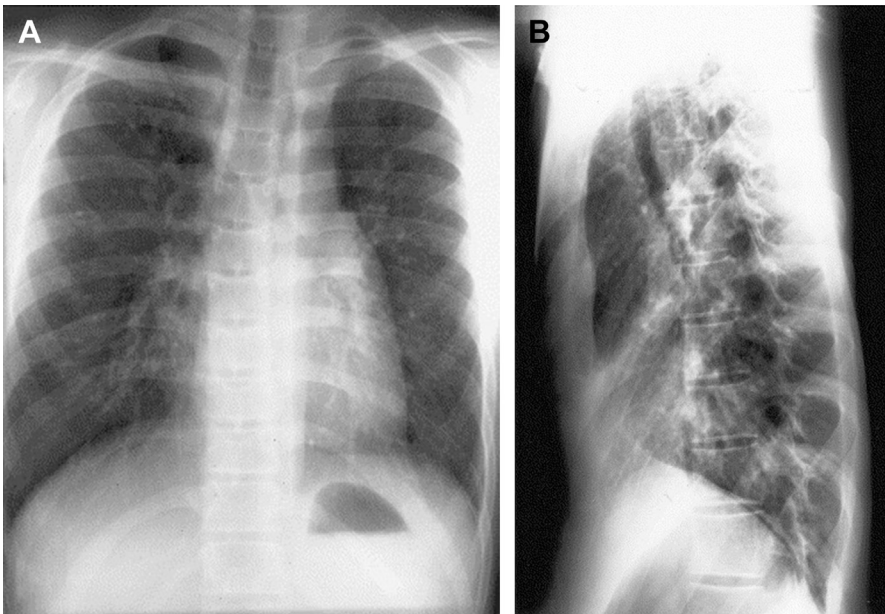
A patient with SBS who required operation for tracheal compression (same as Fig. 1). (A) Chest radiograph anterior-posterior view demonstrating clear lung fields and slightly widened trachea. (B) Lateral view demonstrates a narrow chest with no dorsal curvature of the thoracic spine. (From Grillo HC, Wright CD, Dartvelle PG, et al. Tracheal compression caused by straight back syndrome, chest wall deformity and anterior spine displacement: techniques for relief. *Ann Thorac Surg* 2005;80:2059; with permission.)
